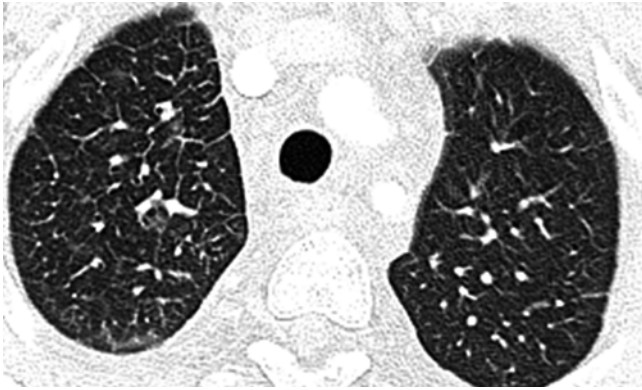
Niemann–Pick type B in a 2-year-old girl. Axial lung window CT image demonstrates diffuse thickening of the pulmonary interstitium
